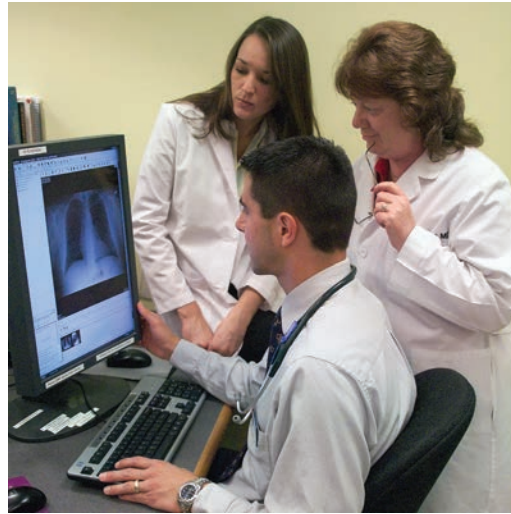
Health care providers viewing an electronic image of a patient's chest x-ray.
